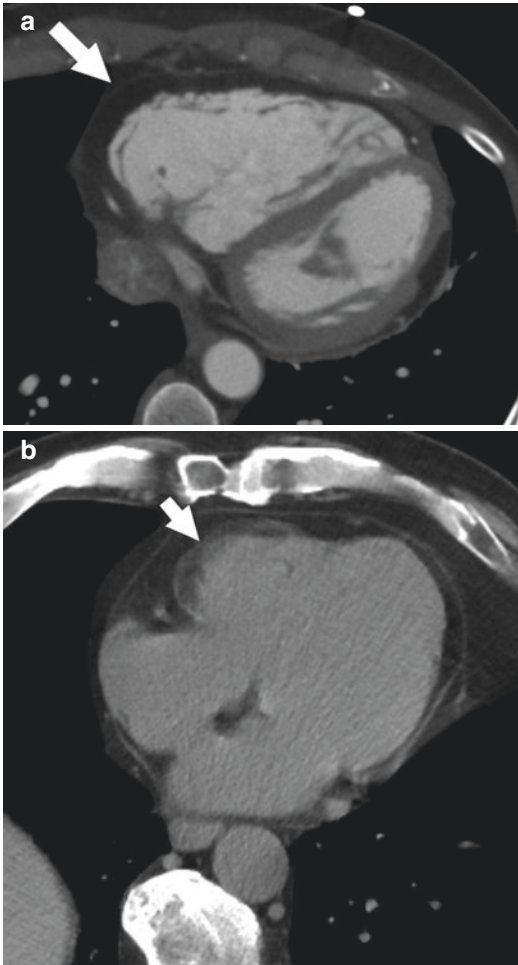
Cardiomyopathy. (a) Axial contrast enhanced CTA image shows dilated right ventricle along with fat deposition in the right ventricular myocardium (arrow), indicative of arrhythmogenic right ventricular dysplasia. (b) Axial non contrast CT in another patient with ARVD shows fat in the RV myocardium (arrow)
